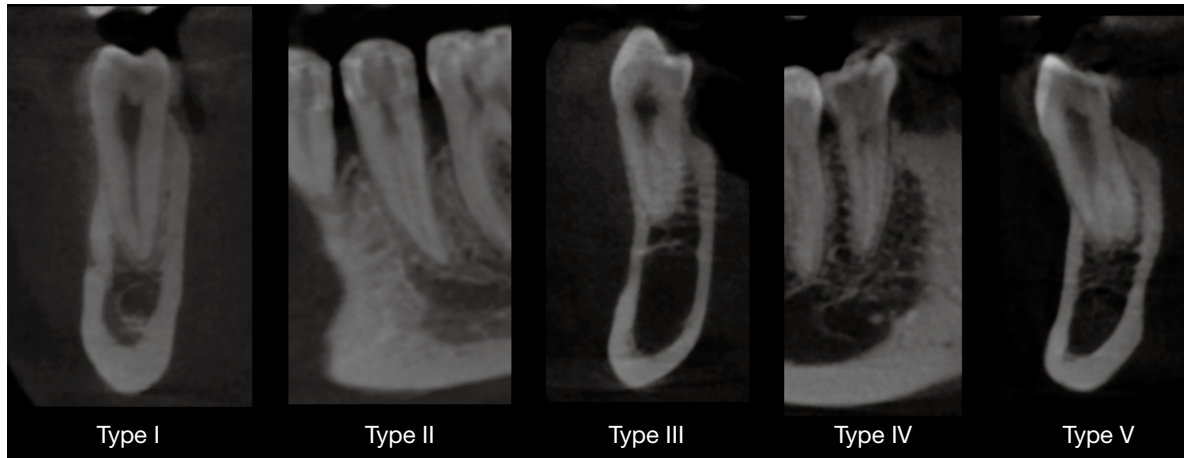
Sagittal (types II and IV) and coronal (types I, III, and V) cone-beam computed tomography reconstructions of the most frequent types of root canal anatomic variations evaluated in the lower premolars according to the Vertucci classification.
